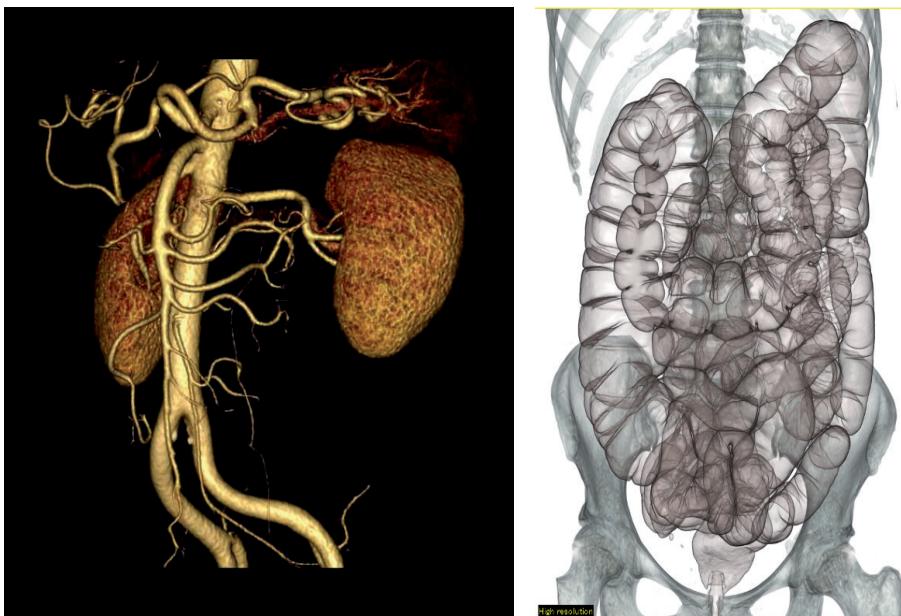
CT angiography. 3-D rendered image of vessels with iodine administered intravenously (left). CT colonography using gas inflated through the rectum (right).
